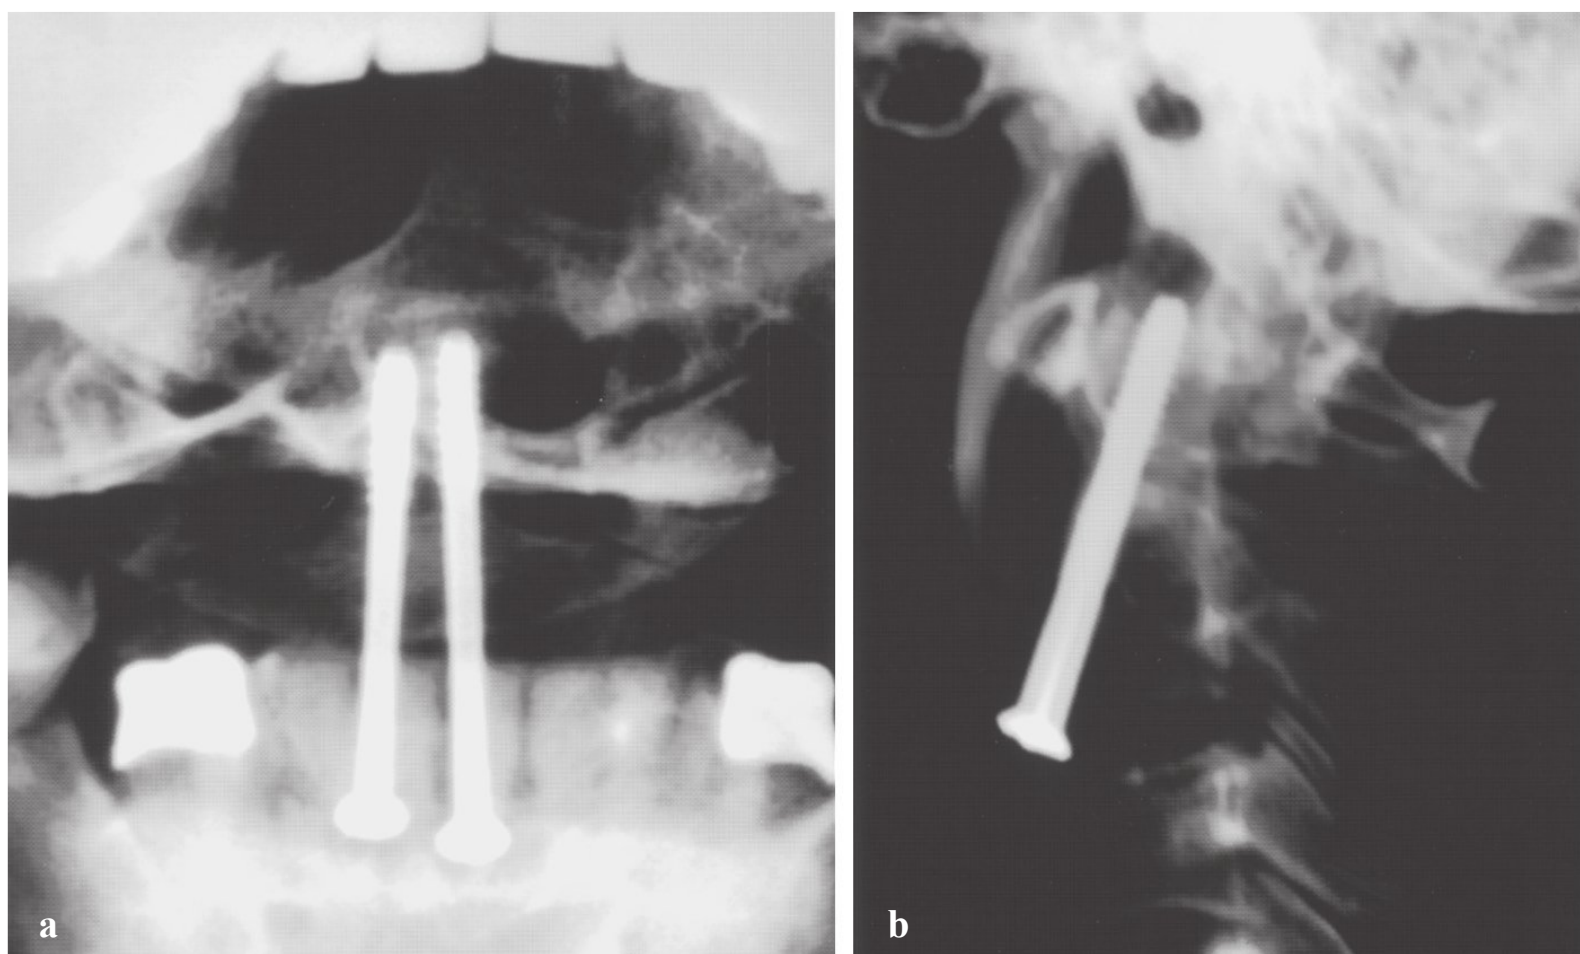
(a) Open mouth and (b) lateral radiographs demonstrating anterior odontoid screw fixation for a C2 dens fracture.
